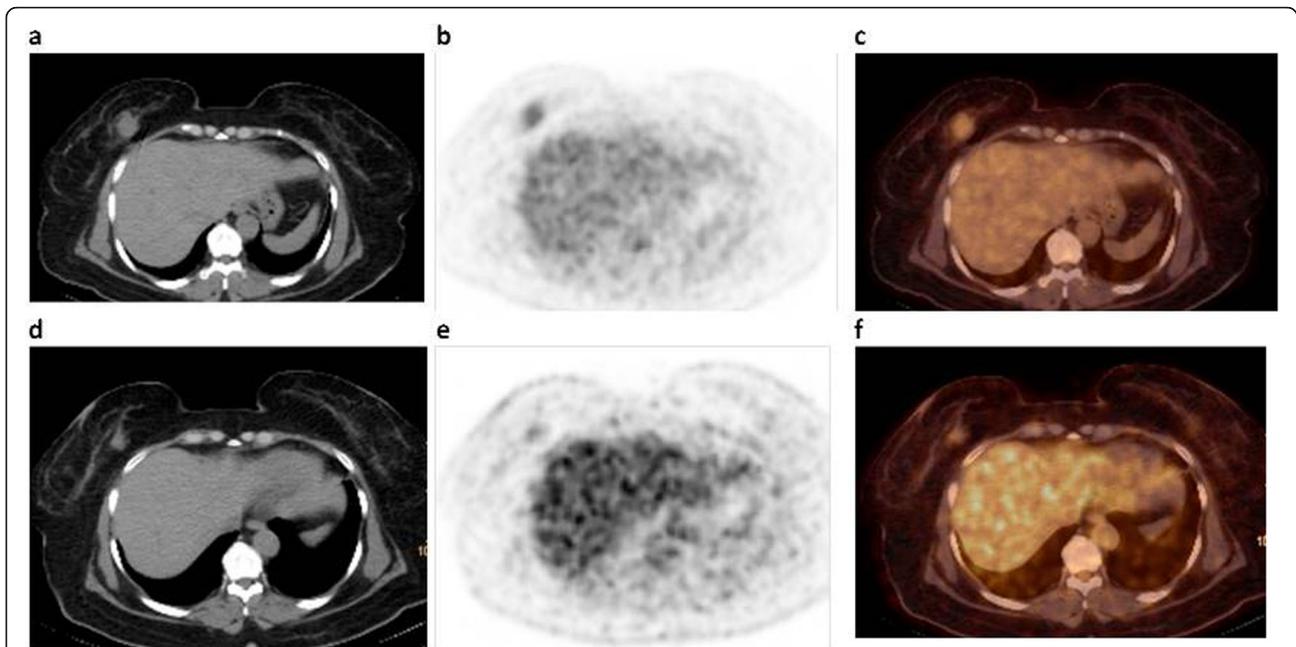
68 years old female patient presented with right breast lump biopsy revealed invasive duct carcinoma grade II (luminal A subtype). Axial CECT image (a) revealed a rather defined right breast soft tissue mass lesion measuring about 29 × 36 mm at lower inner quadrant that was eliciting increased tracer uptake reaching 5 SUL_{peak} in axial PET (b) and fused PET/CT (c) images. On follow-up after completion of chemotherapy, morphologic and metabolic regression of the mass was noted in the form of reduction in size (reaching 9 × 16 mm) in axial CECT image (d) denoting partial response and reduction in SUL_{peak} (reaching 2.1) in axial PET (e) and fused PET/CT (f) images denoting partial metabolic response
